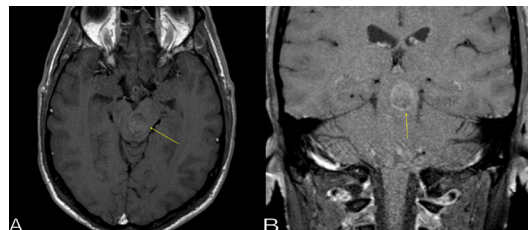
Brain MRI (A) axial and (B) coronal views of the delayed contrast-enhanced T1-weighted images showing contrast rim-enhancement (yellow arrow).
